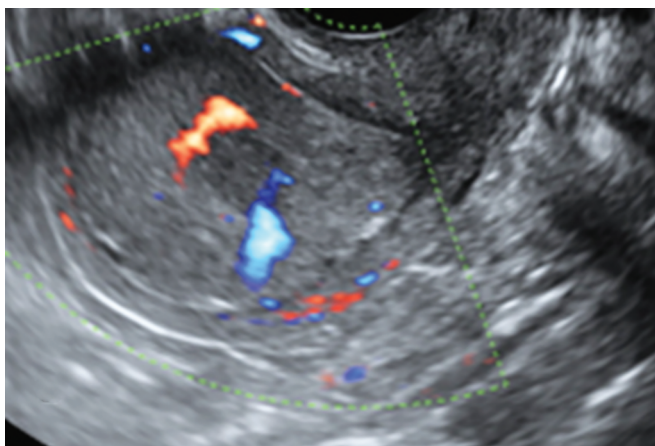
2D color Doppler ultrasound of the lesion detected moderate vascularity "color score 3"
